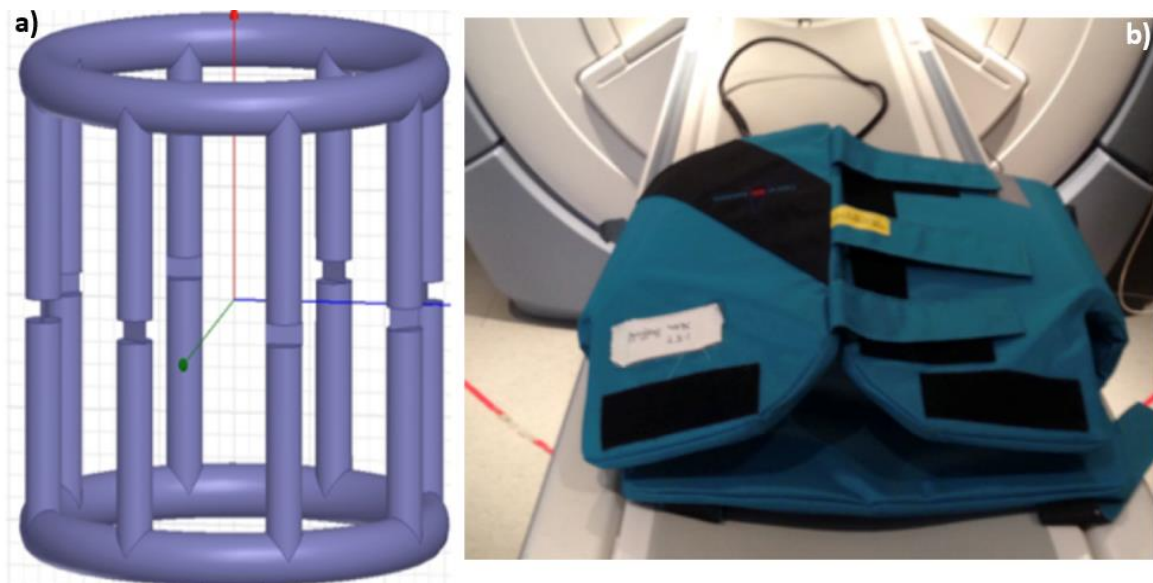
Vest coil commonly used for clinical MRI scans on the left (vest coil CRMS, Wisconsin, USA) and a 3D cad of a low pass birdcage: the gap in the middle of the legs are the capacitors. ©University of Sheffield.
